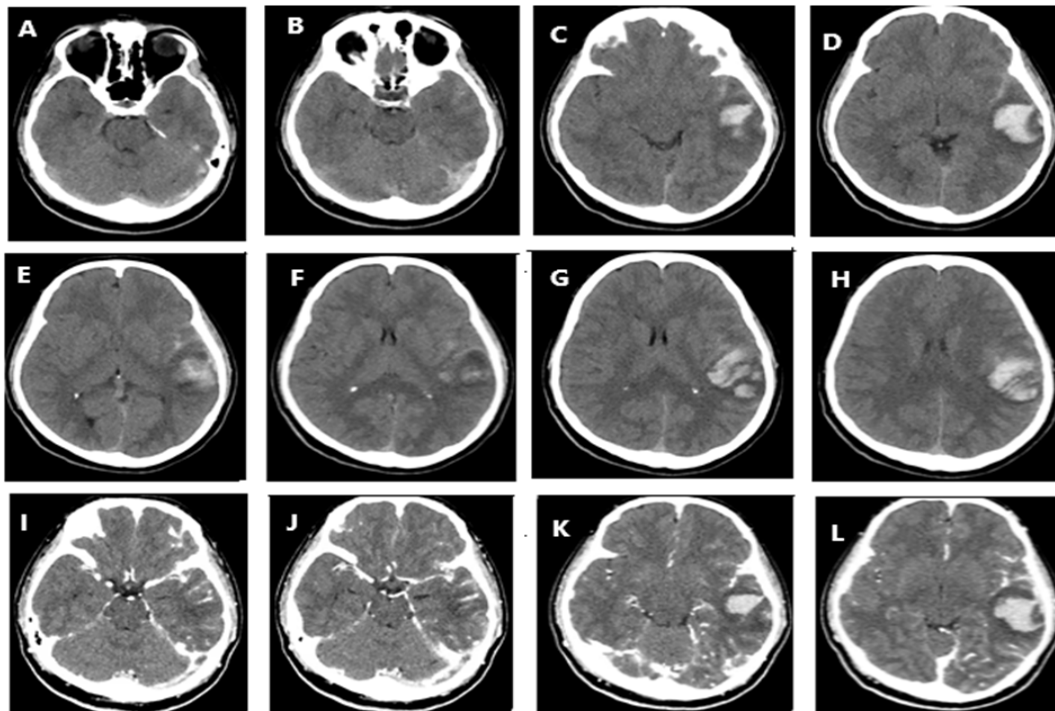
CT brain venography with contrast injection showed that the left transverse and sigmoid dural venous sinuses appear of increased attenuated density in the non-contrast study and nonopacified in the contrasted study which signifying venous thrombosis. The left internal jugular vein is also seen non opacified at the level of the the jugular foramen Figure 1 (I-L).
